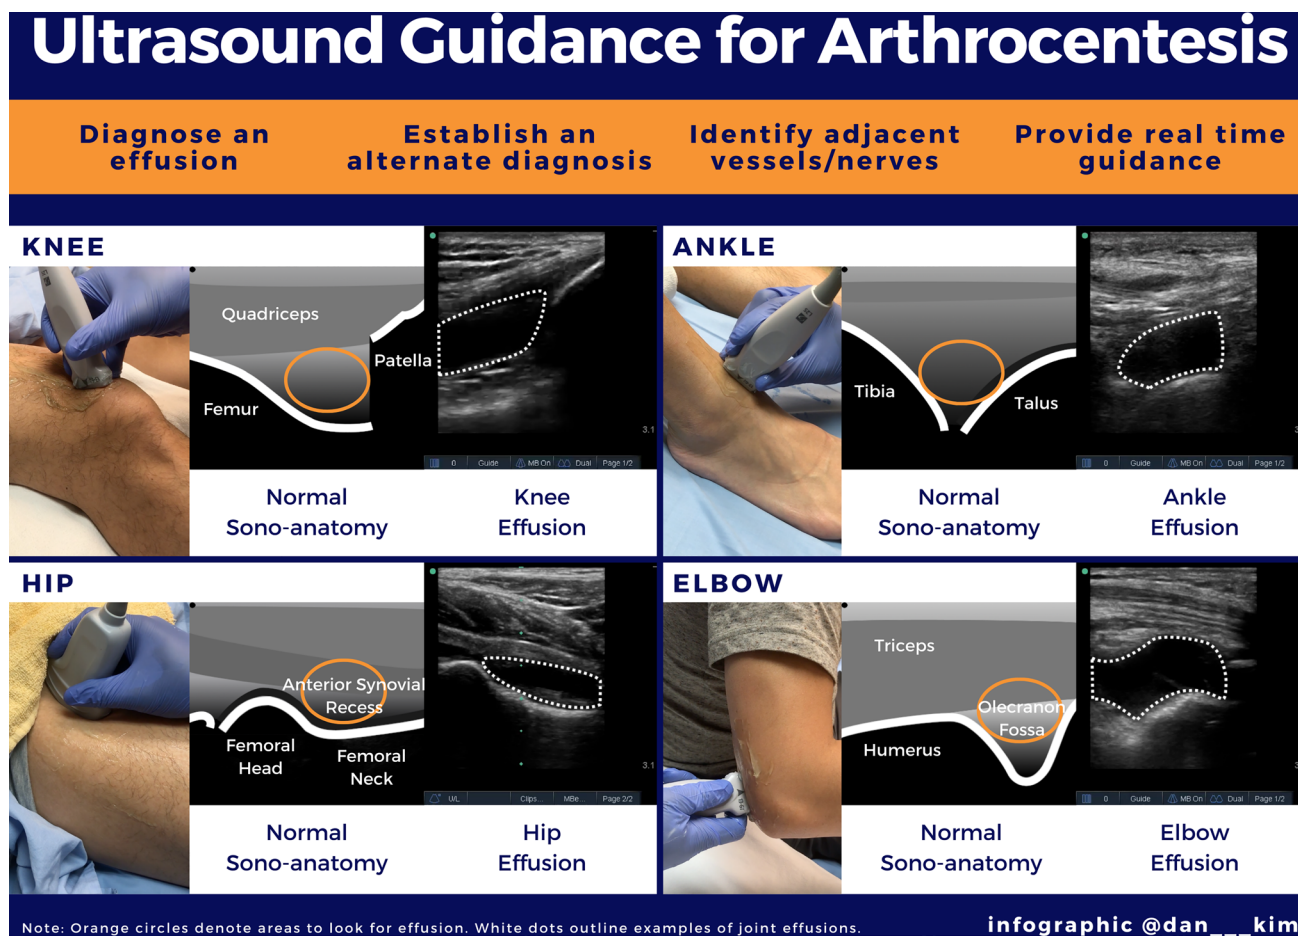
Approach to identifying joint effusions in the knee, ankle, hip, and elbow using point of care ultrasound
